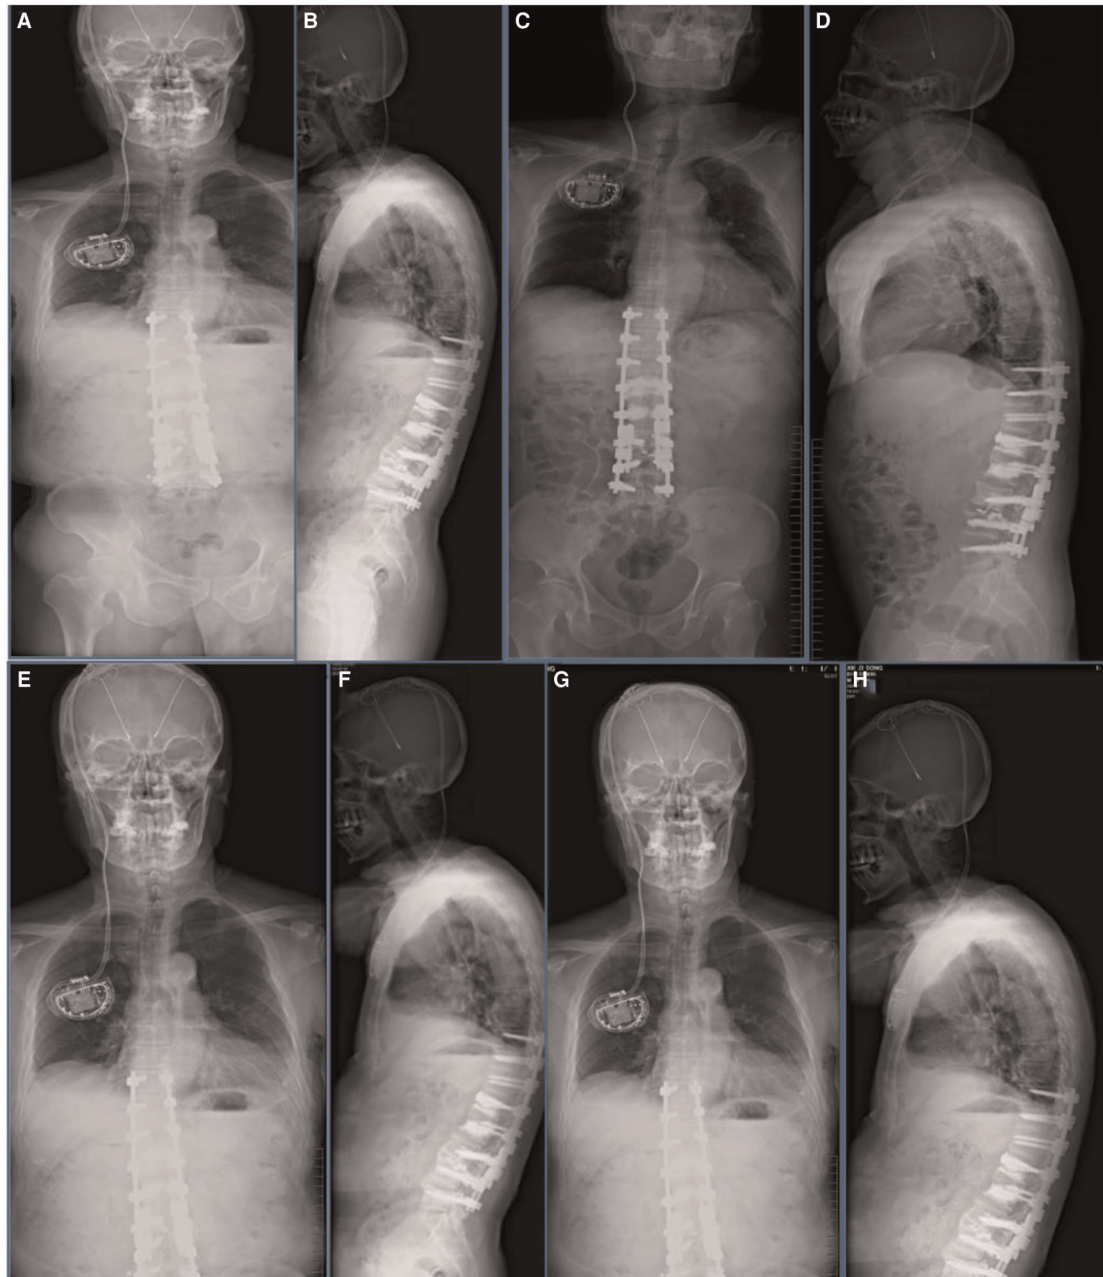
Imaging findings after revision surgery at our hospital. (A,B) One-month follow-up postoperative radiograph indicated good spinal stability without loosening of the screws. (C,D) Three-month follow-up postoperative radiograph indicated good spinal stability without loosening of the screws. (E,F) The patient's radiograph was reviewed 6 months after surgery and showed the good orthopedic status of the spine without loosening of the internal fixation screws. (G,H) Follow-up radiographs taken 1.5 years after surgery showed no loosening of the internal fixation and good spinal orthopedic status.
